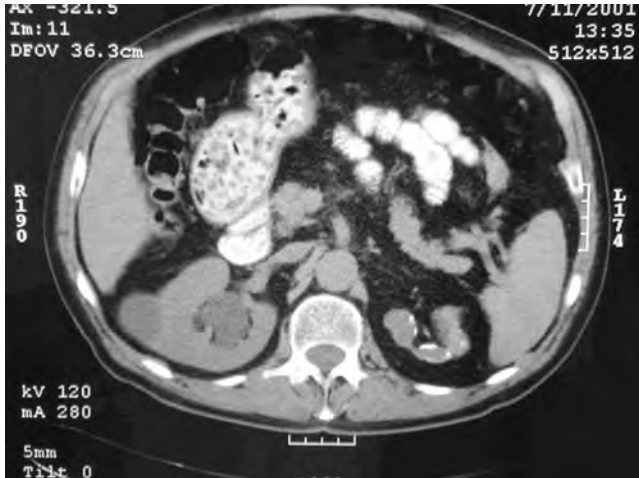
Computed tomography scan after oral contrast medium in a patient with bilateral renal tuberculosis. The right kidney is hydronephrotic secondary to infundibular stenosis but has retained good function. The left kidney is an end-stage nonfunctioning atrophic kidney with calcification.
